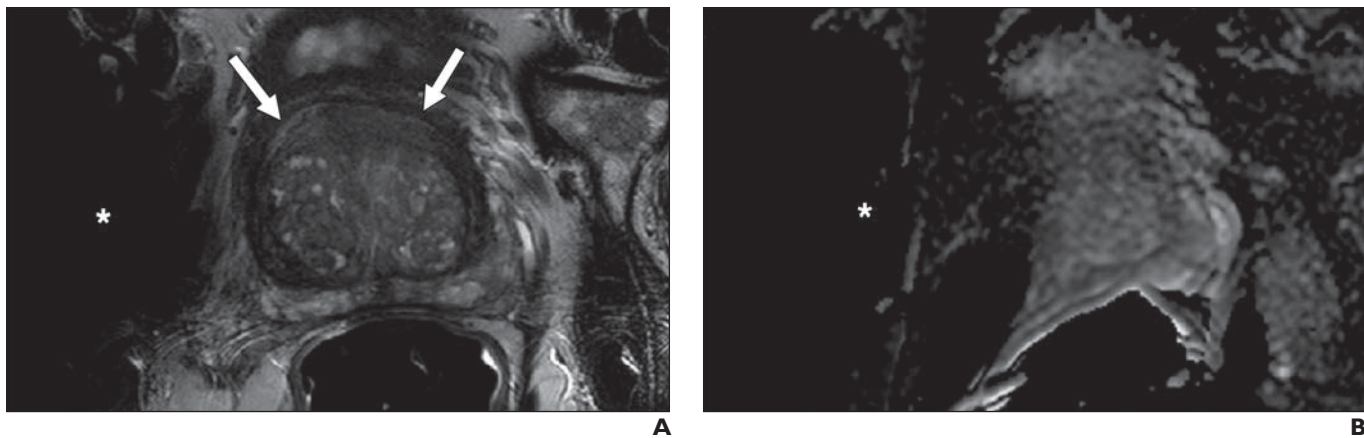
63-year-old man who presented with serum prostate-specific antigen value of 42 ng/mL and history of negative results on 10 previous transrectal ultrasound-guided biopsies; 3-T multiparametric MRI examination was performed with endorectal coil. A, T2-weighted image shows midline anterior transition zone lesion (*arrows*) despite right-sided hip prosthesis artifacts (*asterisk*). B, Apparent diffusion coefficient map is nondiagnostic because of right-sided hip prosthesis artifacts (*asterisk*). Targeted biopsy of lesion shown in A revealed Gleason 4 + 5 prostate cancer.
